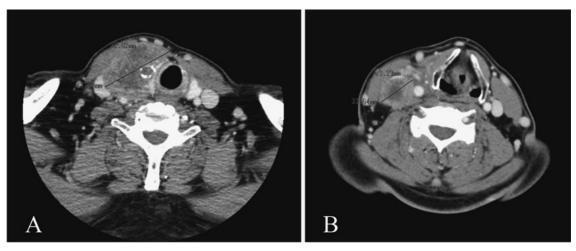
Enhanced cervical computed tomography (CT) findings just before surgery, 1 month after the initial CT scan.
